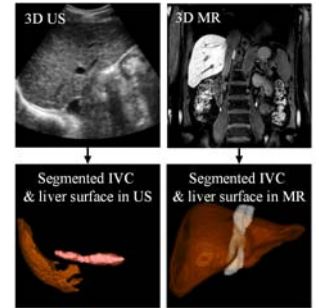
Segmented features obtained from a 3D US image and its corresponding 3D MR image
